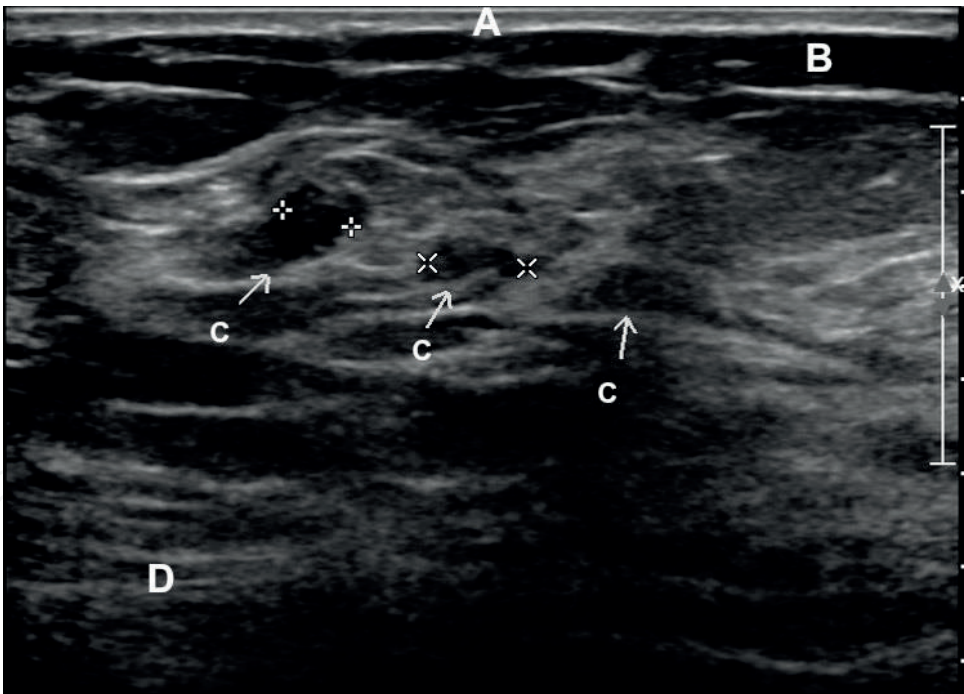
Breast anatomy. Transverse ultrasound shows normal breast anatomy. (A) Skin, (B) subcutaneous fat, (C) terminal duct lobular unit, and (D) muscle.
